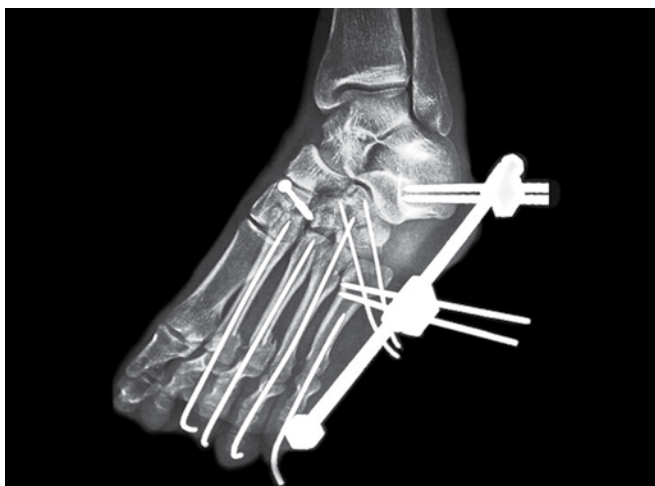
Postoperative radiograph of a nutcracker cuboid fracture associated with a complex midfoot-forefoot injury. The lateral column length was restored by JESS fixator, K-wires were used to stabilize the metatarsal fracture and metatarsophalangeal dislocations and a lag screw was used to fix the middle cuneiform
